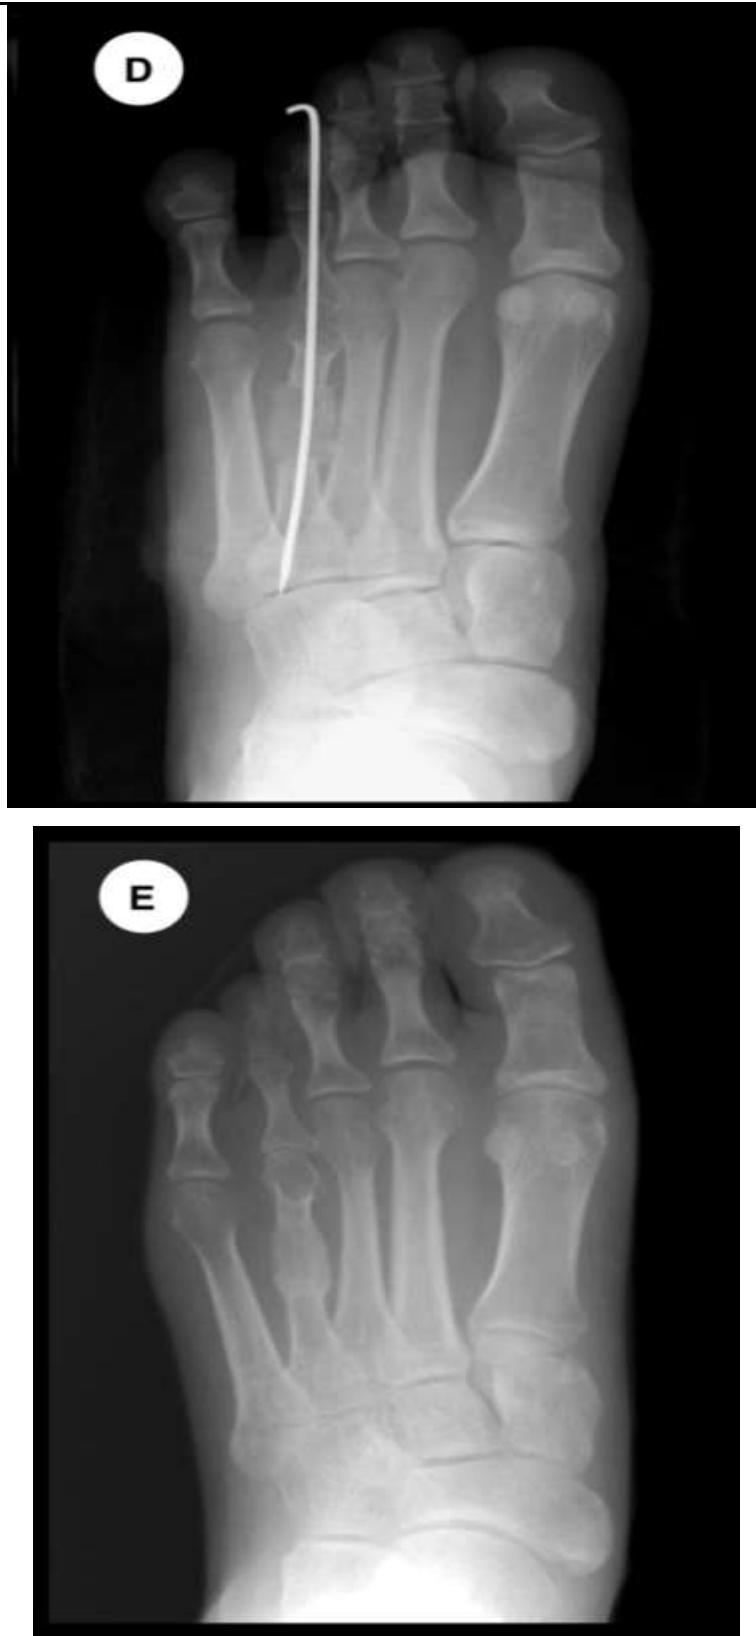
1 The radiographs show an anteroposterior view of before and after operation of bone graft.
